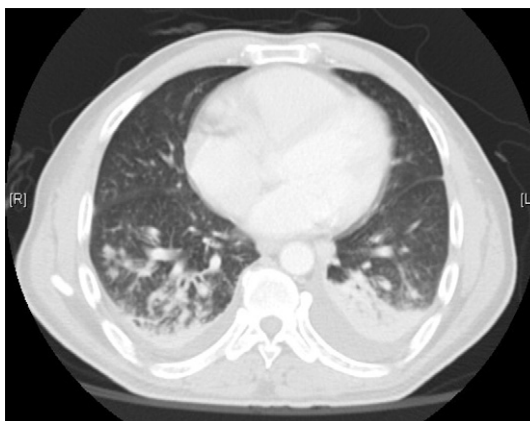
High-resolution computed tomography showed reticulonodular infiltration in bilateral lower lungs with consolidation, located mostly at the posterior segments of both lung lobes with prominent left-sided pleural effusion.
